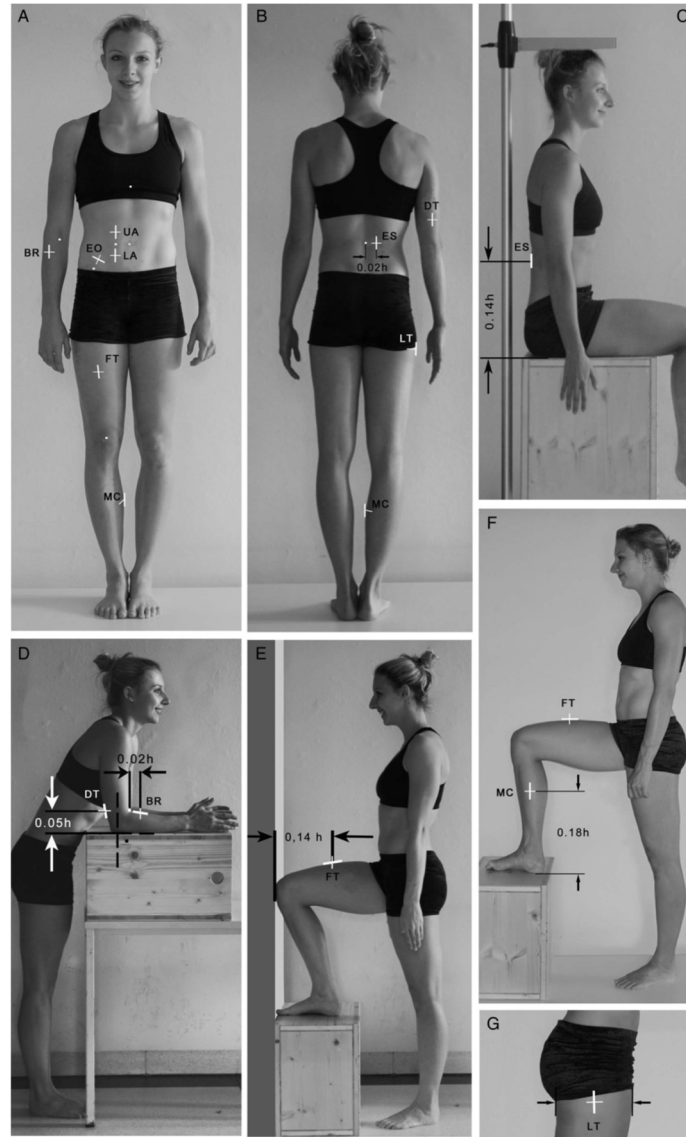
Ultrasound sites: Note, that the site EO (external oblique) was replaced by the lateral thigh because it caused measurement problems in obese individuals and had a worse reliability. Furthermore, the lateral thigh site is a typical location for fat depots in women (Müller et al., 2016).
